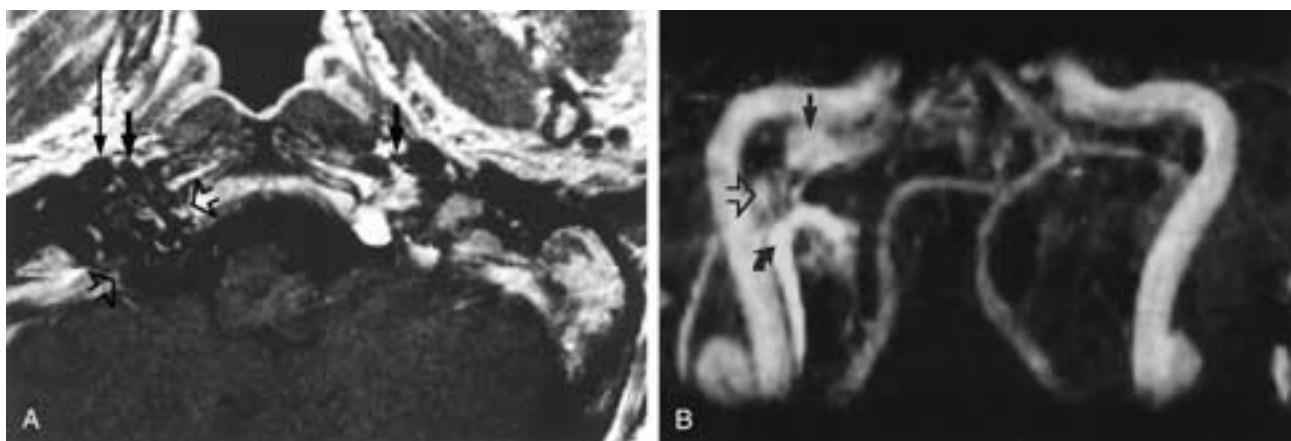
DAVF. The patient developed increasing right pulsatile tinnitus of gradual onset over a 2-year period after head trauma. No basal skull fracture was found on high-resolution CT. A, Gadolinium T1-weighted image. The long arrow points to the right internal carotid artery; short arrows point to the enlarged right and normal left ascending pharyngeal arteries. A cluster of serpentine “flow voids” without an associated soft-tissue mass lies posterior to the right internal carotid and ascending pharyngeal arteries and between the open arrows. B, MRA 3D time-of-flight technique, maximum intensity projection. The hypertrophic right ascending pharyngeal artery (*curved arrow*) and a cluster of dilated vessels (*open arrow*) lie immediately medial, and a dilated inferior petrosal sinus (*arrow*) lies inferior to the right internal carotid artery.
